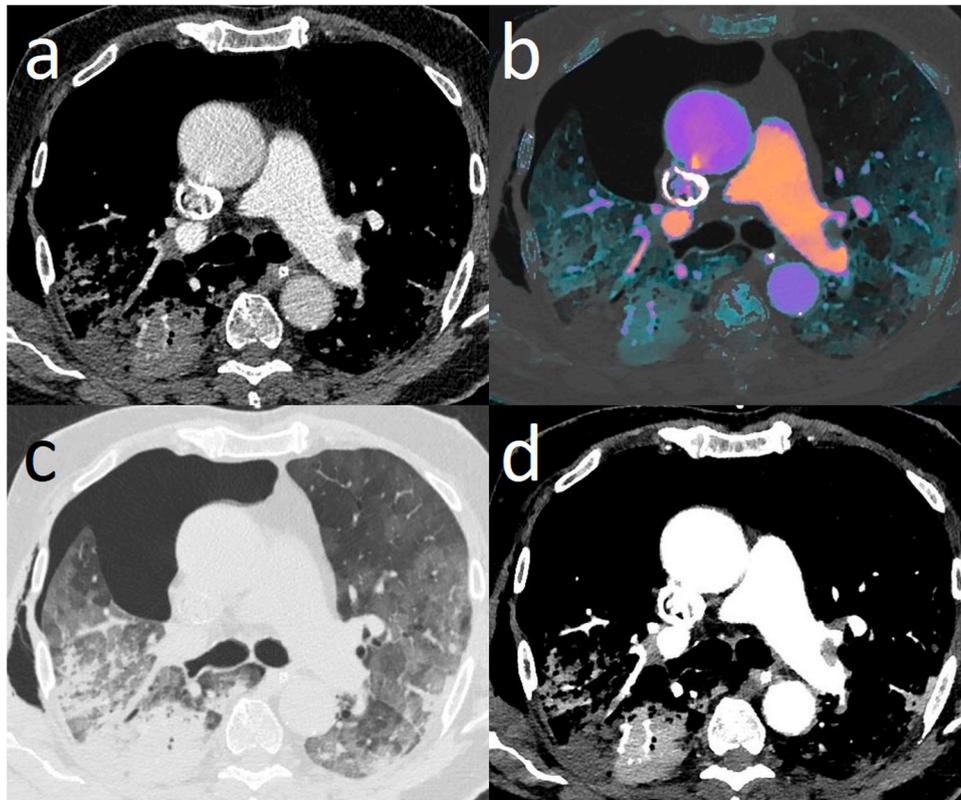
CT image of pulmonary embolism in patient with complicated COVID-19 pneumonia. a. Conventional (Hounsfield unit) CT image. b. Fusion of iodine density maps and conventional image. c. Virtual non-contrast image, lung window. d. Virtual low-energy monoenergetic image (55 keV). Visible are contrast filling defects in pulmonary arteries (left in lobar/segmental branching, right in segmental branch). Wedge-shaped defect in perfusion (dorsal parts of right lung) in hyperaemic consolidation. Diffuse ground-glass opacities in both lungs, corresponding with COVID-19 pneumonia. Right side pneumothorax and thoracic wall emphysema.
